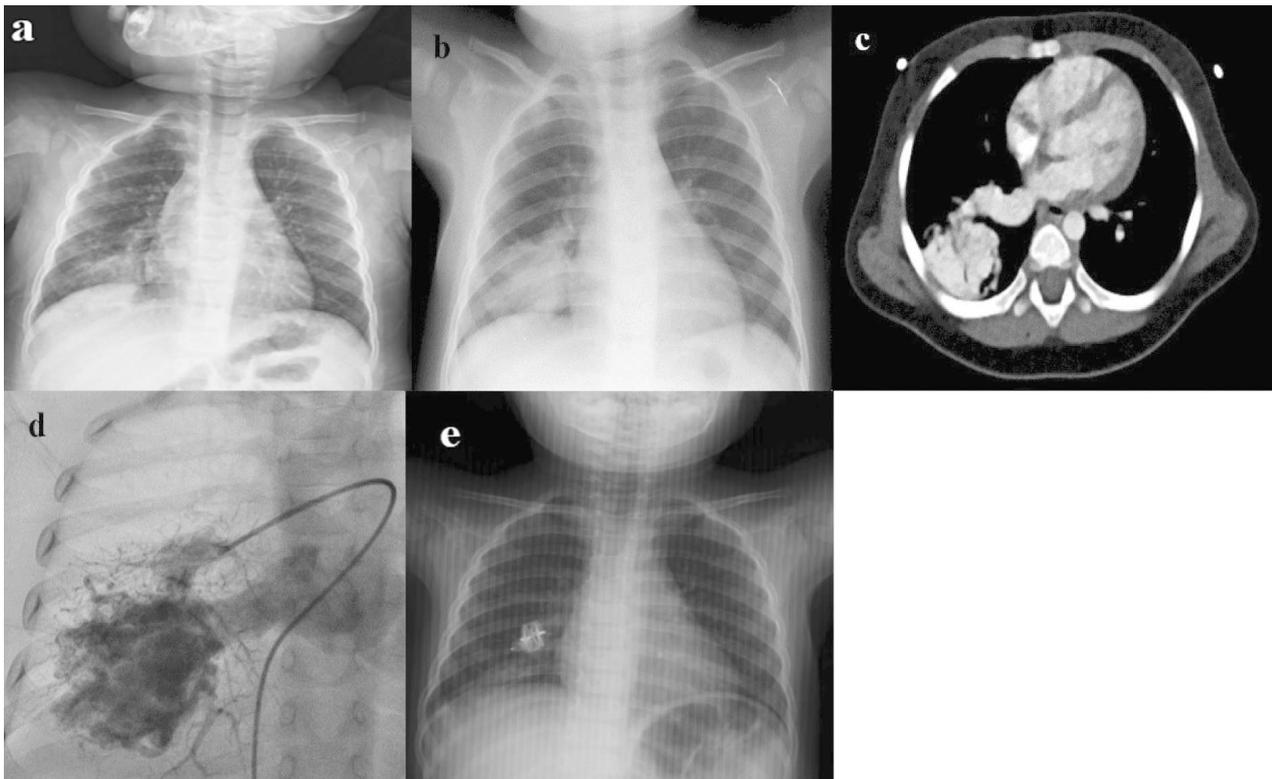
(a) Anterior-posterior chest X-ray at the time of presentation; infiltration in the inferior lobe of the right lung. (b) Radiograph on the 7th day of treatment; increased density in a round form 3-4 cm in diameter in the inferior basal of the right lung. (c) Thoracic CT; intense contrast involvement consistent with vascular malformation and dilated pulmonary vein draining to the left atrium. (d) Pulmonary angiography; intense contrast involvement consistent with PAVM and draining vein below. (e) Follow-up anterior-posterior chest X-ray following the application of Amplatzer Vascular Plug.
